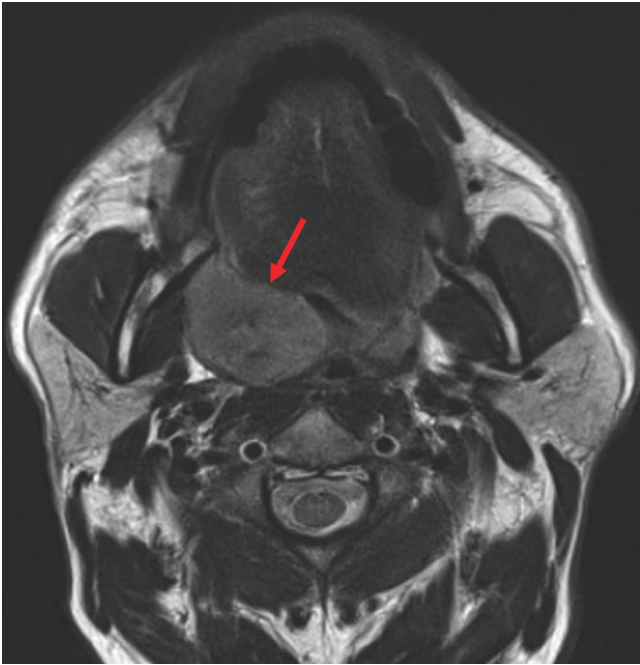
HPV-associated oropharyngeal SCCa of the right lateral palatine tonsil. T2W MR image shows a well-defined exophytic appearance of the mass at the right lateral wall of the oropharynx (arrow)
